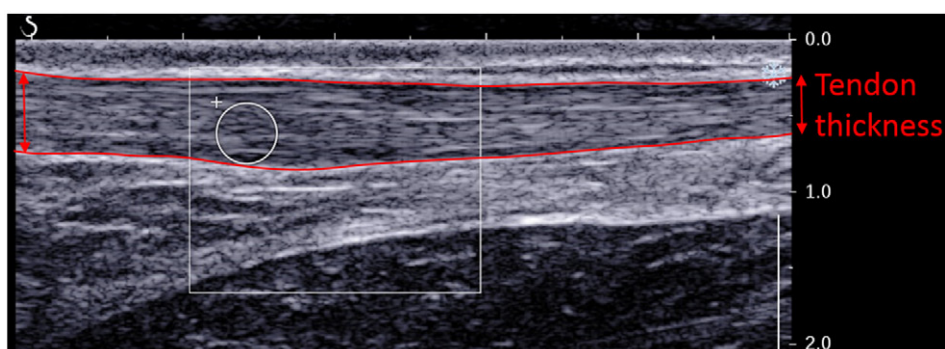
Ultrasound image (Bmode) acquired with SL 15-4 probe on the tendon for subject #9 at an angle of -25° . Thickness was measured on the left on right part (red arrows) to obtain a mean value of the tendon thickness.
